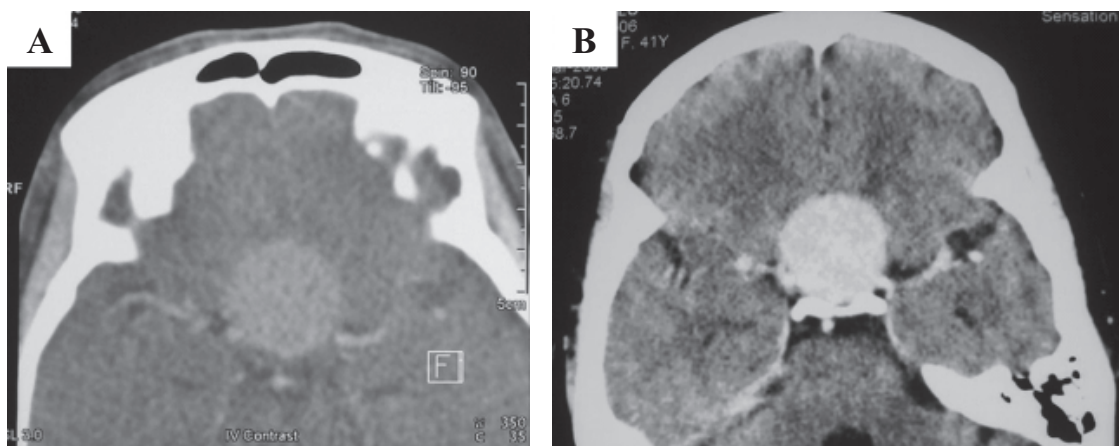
CT brain, axial view. Figure 3A: Plain CT brain revealed a homogenous hyperdense globular mass at the parasellar region. Figure 3B: The mass enhanced homogeneously with intravenous contrast agents.
